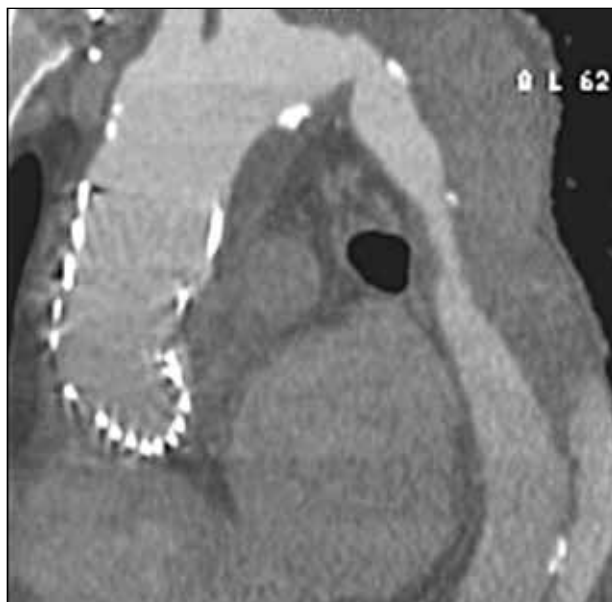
Four-year follow-up CT scan showing partial false lumen thrombosis of the descending aorta.
